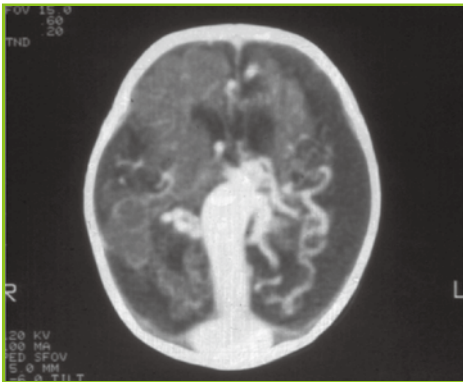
CT scan of a neonates with Aneurysm of the Vein of Galen showing the hugely dilated venous channels and markedly atrophy cerebrum due to steal phenomenon.
